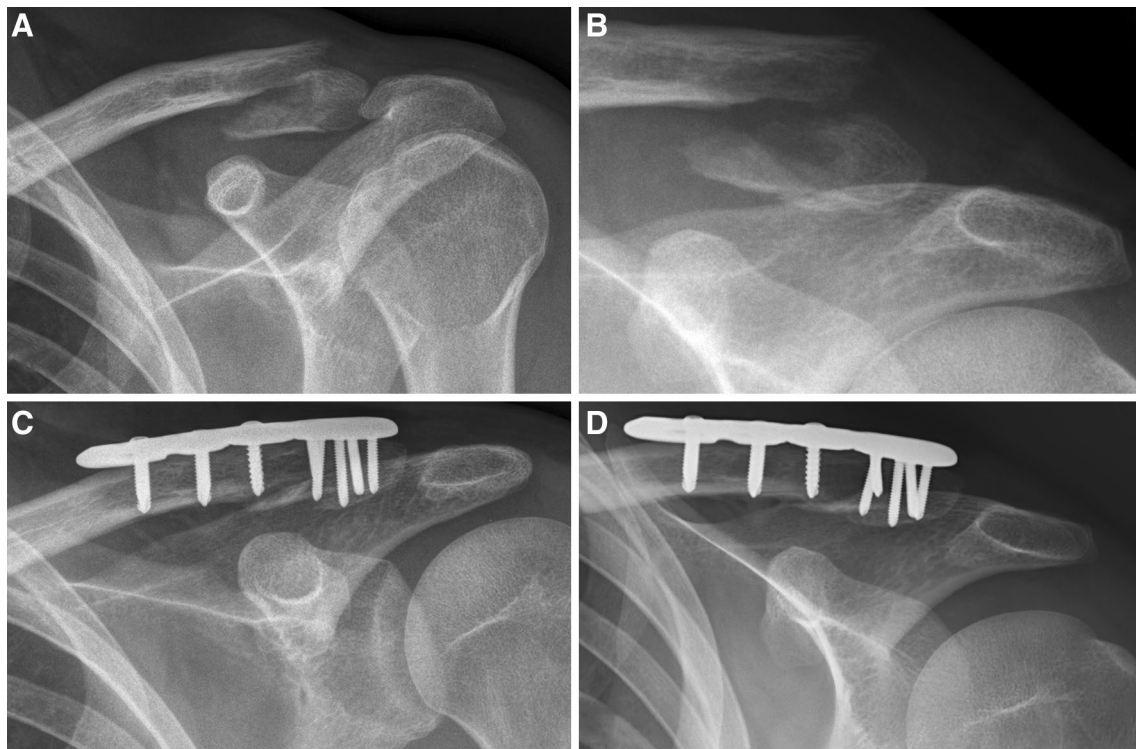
Example of LPO of a Neer IIB fracture. anterior–posterior view without weight (a), anterior–posterior stress radiography with 10 kg vertical loading (b), anterior–posterior view of consolidated
